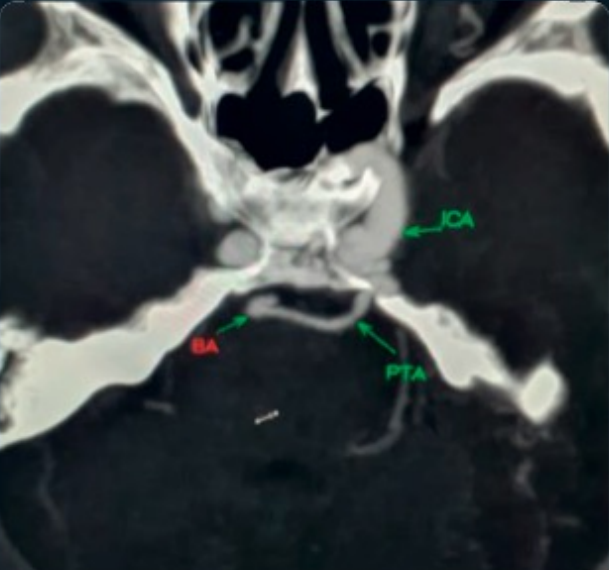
CTA Maximum intensity projection. ICA - internal carotid artery, PTA - persistent trigeminal artery BA - Basilar artery.
